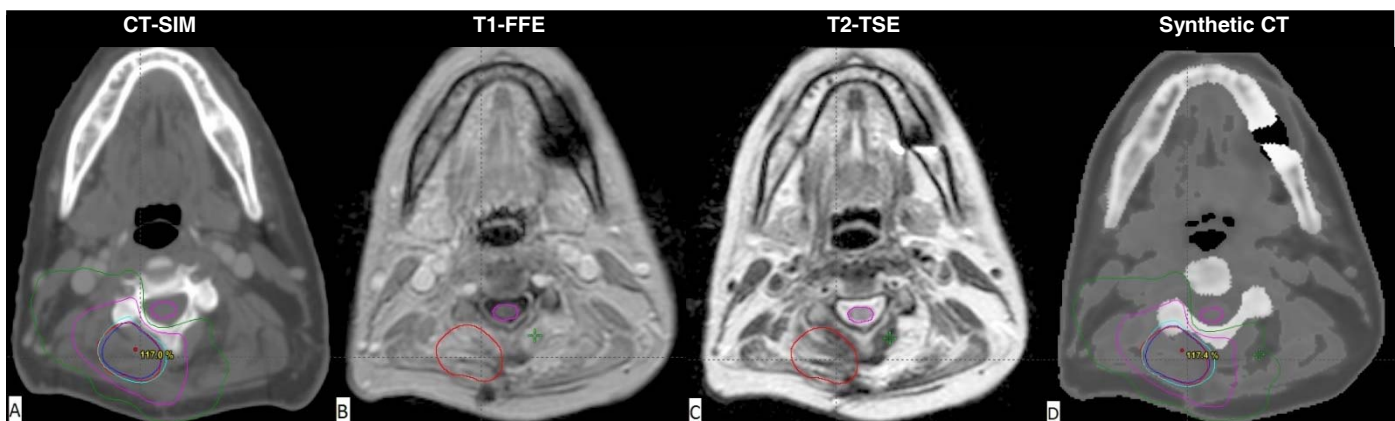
An axial slice with tumor and cord contoured on (a) CT-SIM, (b) T1-FFE, (c) T2-TSE and (d) SynCT. The isodose lines shown on both CT and SynCT images are 90% - prescription isodose line (blue), 80% (cyan), 50%(magenta) and 30%(green) correspondingly.
